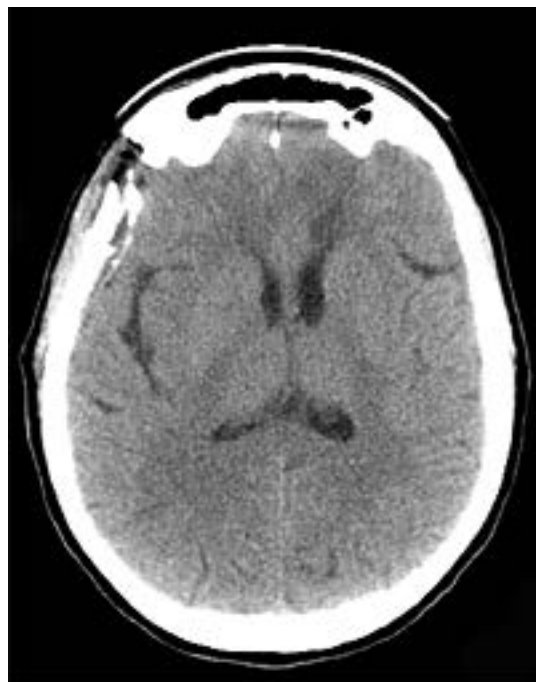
A Post-infusion CT Scan Showing the Absence of Ischemic Areas
